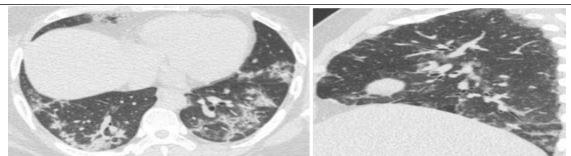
LAxial HRCT Thorax showing crazy paving pattern in a COVID 19 RT-PCR positive.
